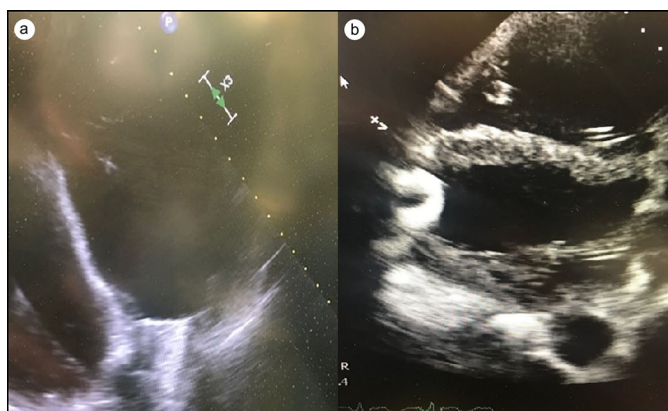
Echocardiograms (a) intraoperatively and (b) on the day of discharge.
